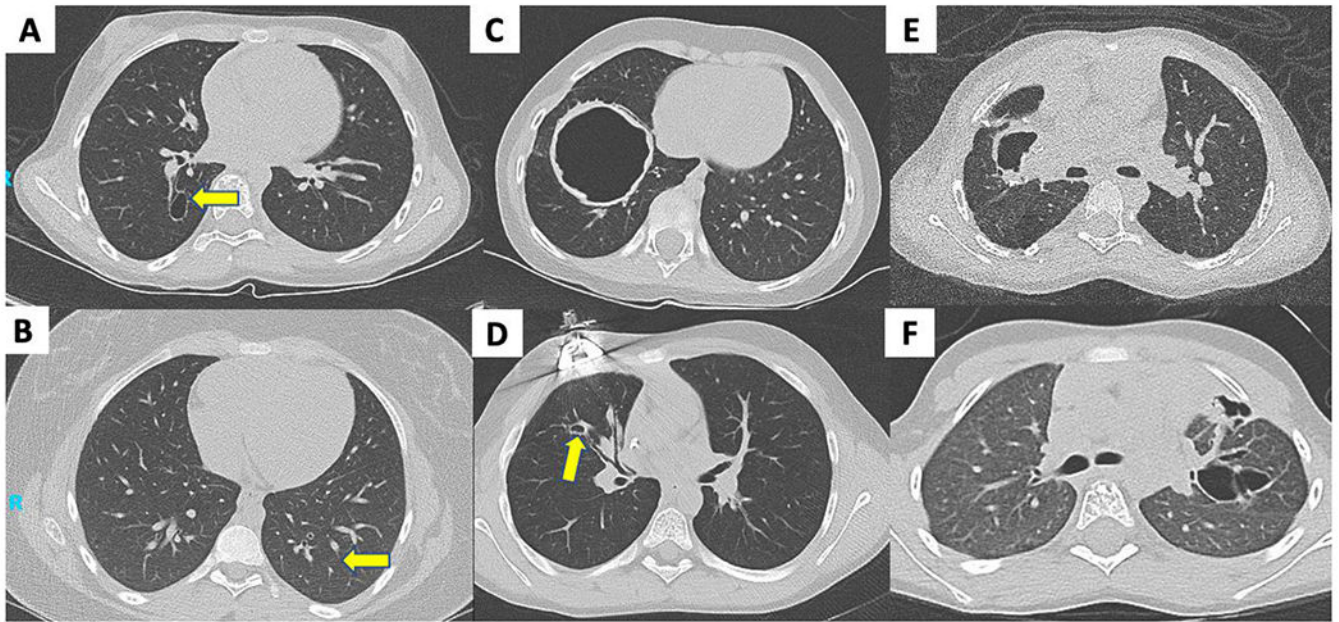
Parenchymal lung findings on CT. (A) small pneumatocele in 12-year-old with family history; (B) subtle bronchiectasis in 13-year-old with family history (C) large pneumatocele in 7-year-old proband; (D) bronchiectasis and small pneumatocele in 10-year-old proband with prior lobectomy; (E) pneumatocele in 9-year-old with prior lobectomy; (F) cystic bronchiectasis in 6-year-old with prior pneumothorax and bronchopleural fistula.
